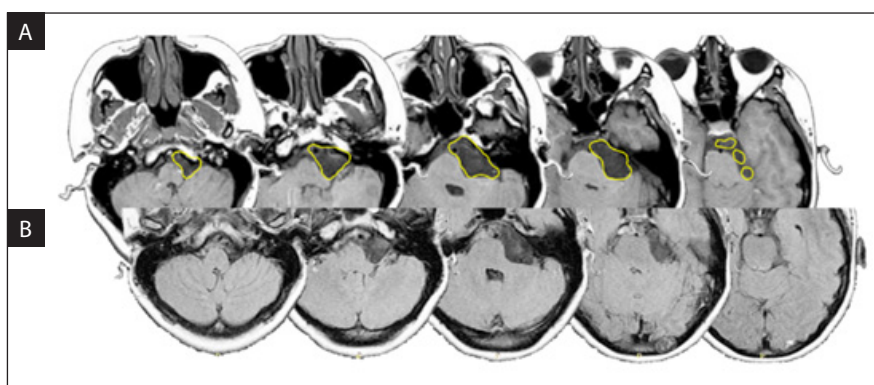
A. Pre-Gamma Knife MRI of patient 3 with a 13.7cc epidermoid tumor treated with 10Gy; B. Post-Gamma Knife MRI of patient 3 52.4 months showing tumor shrinkage
